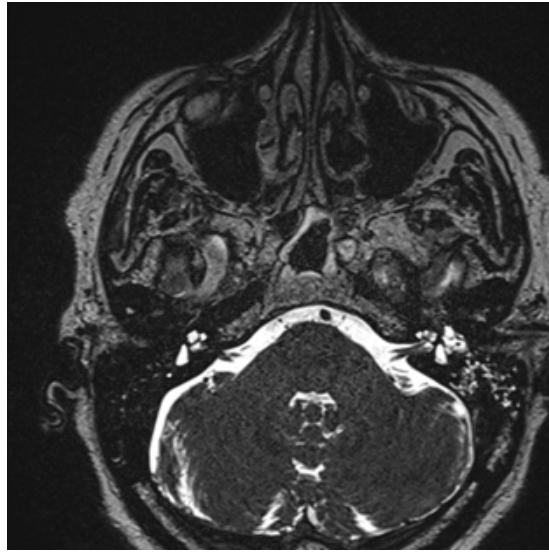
Preoperative magnetic resonance imaging with contrast enhancement. T2-weighted transverse p2_iso sequence (0.6 mm) obtained on the day of the head trauma. Imaging demonstrates an intact cochlear nerve, a fluid-filled inner ear, middle-ear hematoma, and partial opacification of mastoid air cells.
